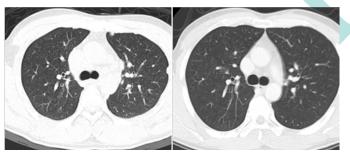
This male of CT image, left before treatment, right after treatment (3 months)
